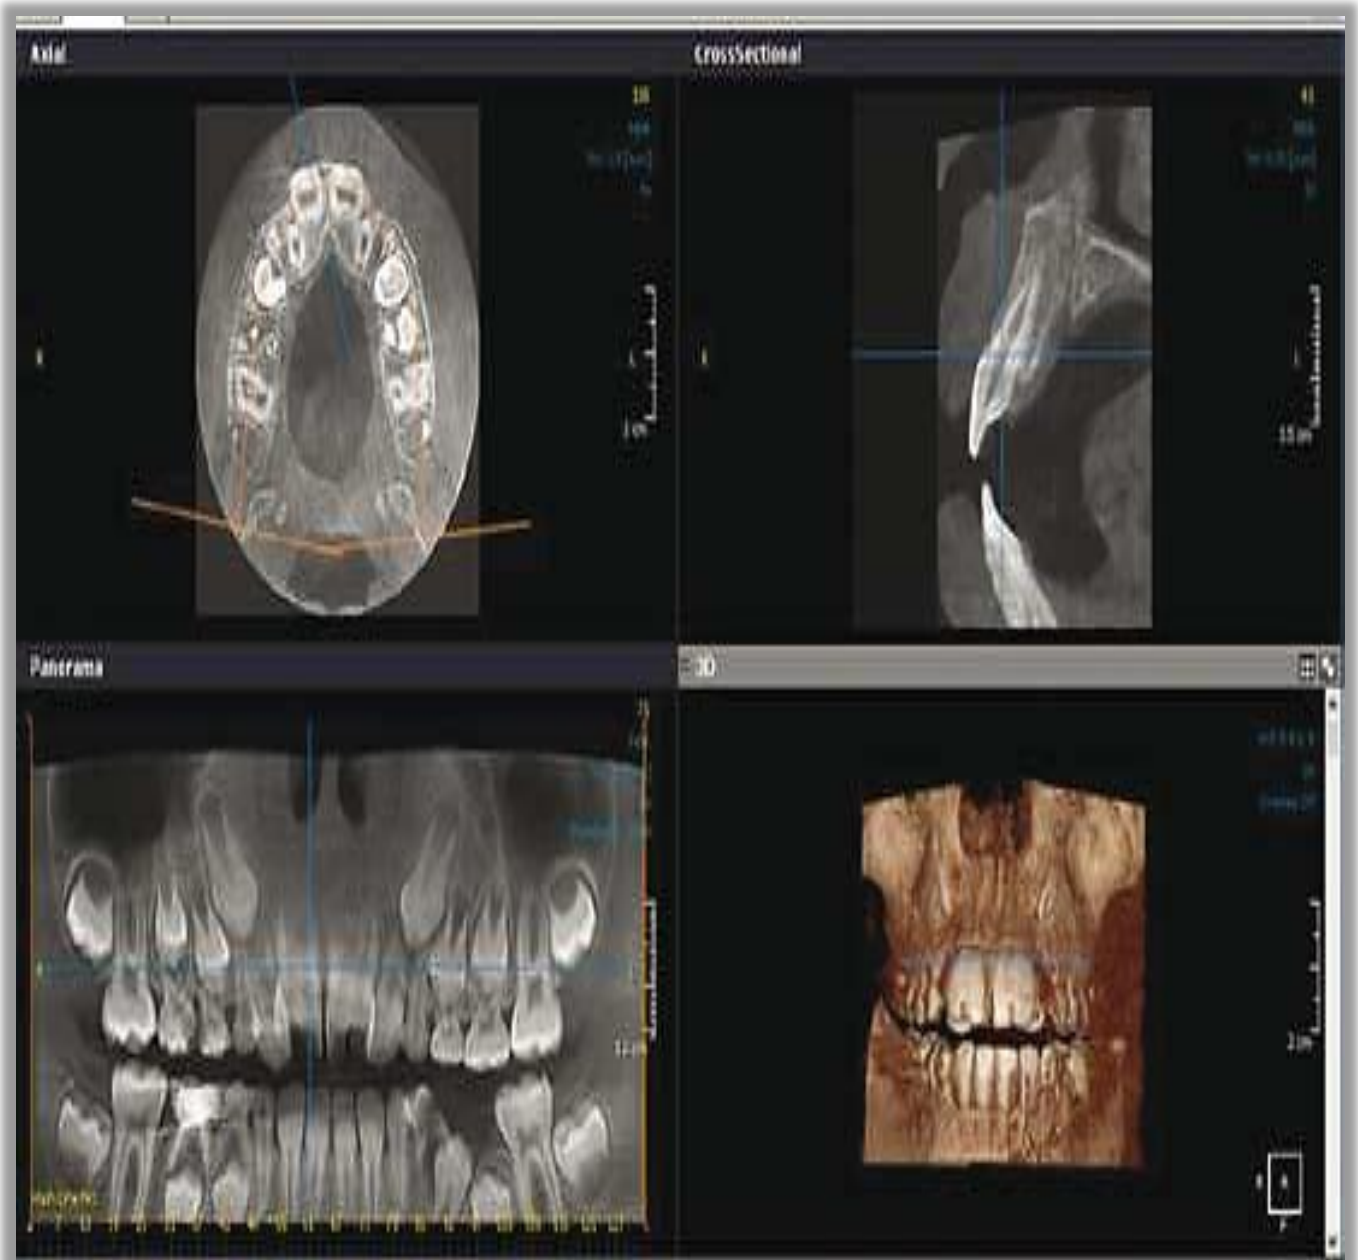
CBCT shows geminated central incisors in panorama, cross sectional, axial, and 3D views (Shokri et al., 2013).
